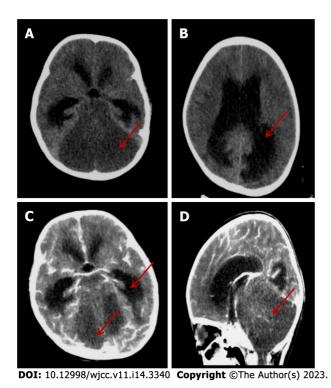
The imaging findings of head computed tomography on day 12 after admission. A: There was a large area of diffuse hypointense signal in the posterior fossa, and the cerebellar parenchymal structure was unclear; B: There was marked dilatation of the supratentorial ventricles and obstructive hydrocephalus with paraventricular edema; C: No parenchymal enhancement mass was found on contrast-enhanced scan; D: The sagittal view showed supratentorial elevation with diffuse brain swelling on contrast-enhanced scan.
